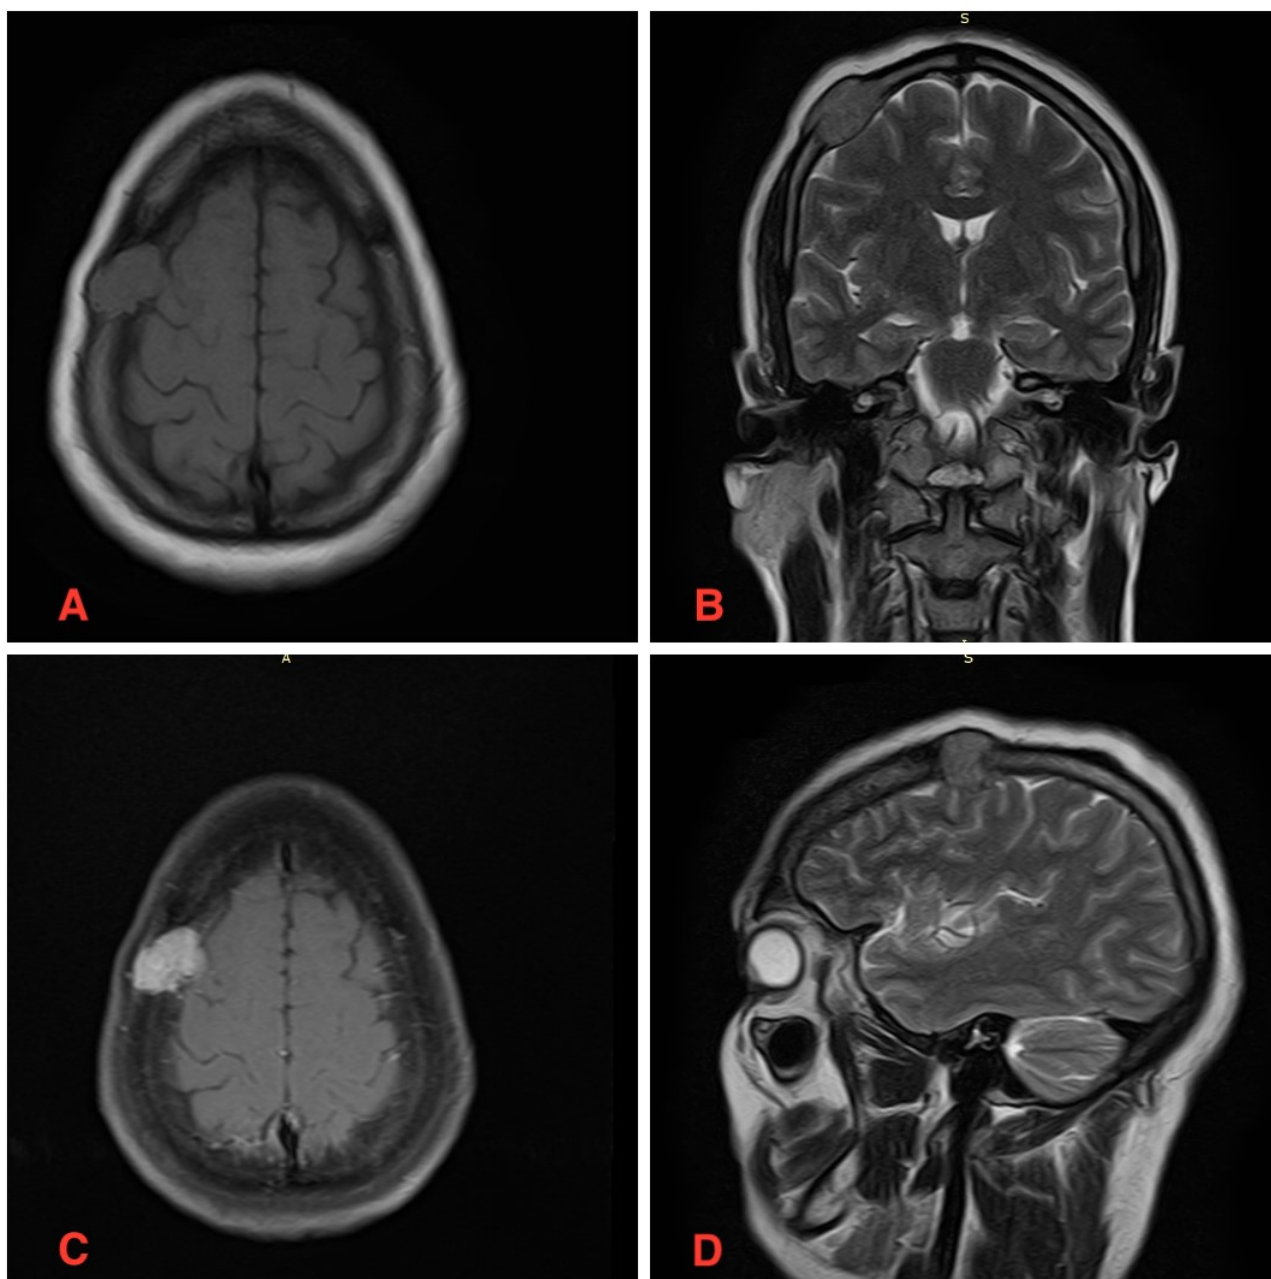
MRI brain. (A) T1 non-contrast demonstrating an extra-axial isointense lesion with bony involvement. (C) T1 post-contrast demonstrating homogeneous enhancement. (B,D) T2 coronal and sagittal images demonstrating an isointense lesion mimicking meningioma. MRI, magnetic resonance imaging.
